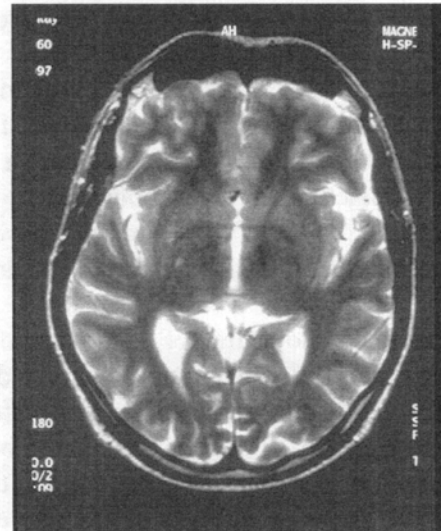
Brain MRI of a control subject, showing similar white matter lesions.
